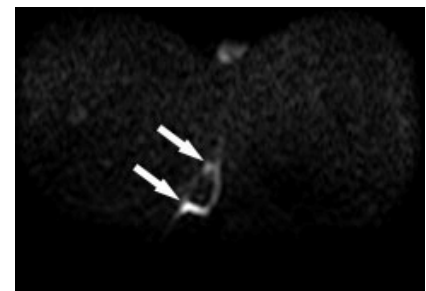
Axial diffusion-weighted MR image clearly shows an anal fistula as marked hyper intensity area (arrows).
